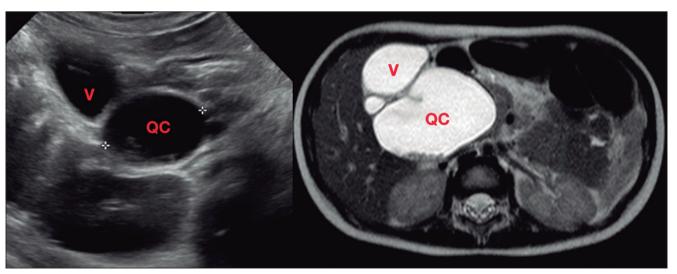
Abdominal ultrasound and cholangio MRI, showing dilation of cysts in the adjacent extrahepatic bile ducts and gallbladder. CC: Coledocal cyst, G: Gallbladder, MRI: Magnetic Resonance Imaging.
